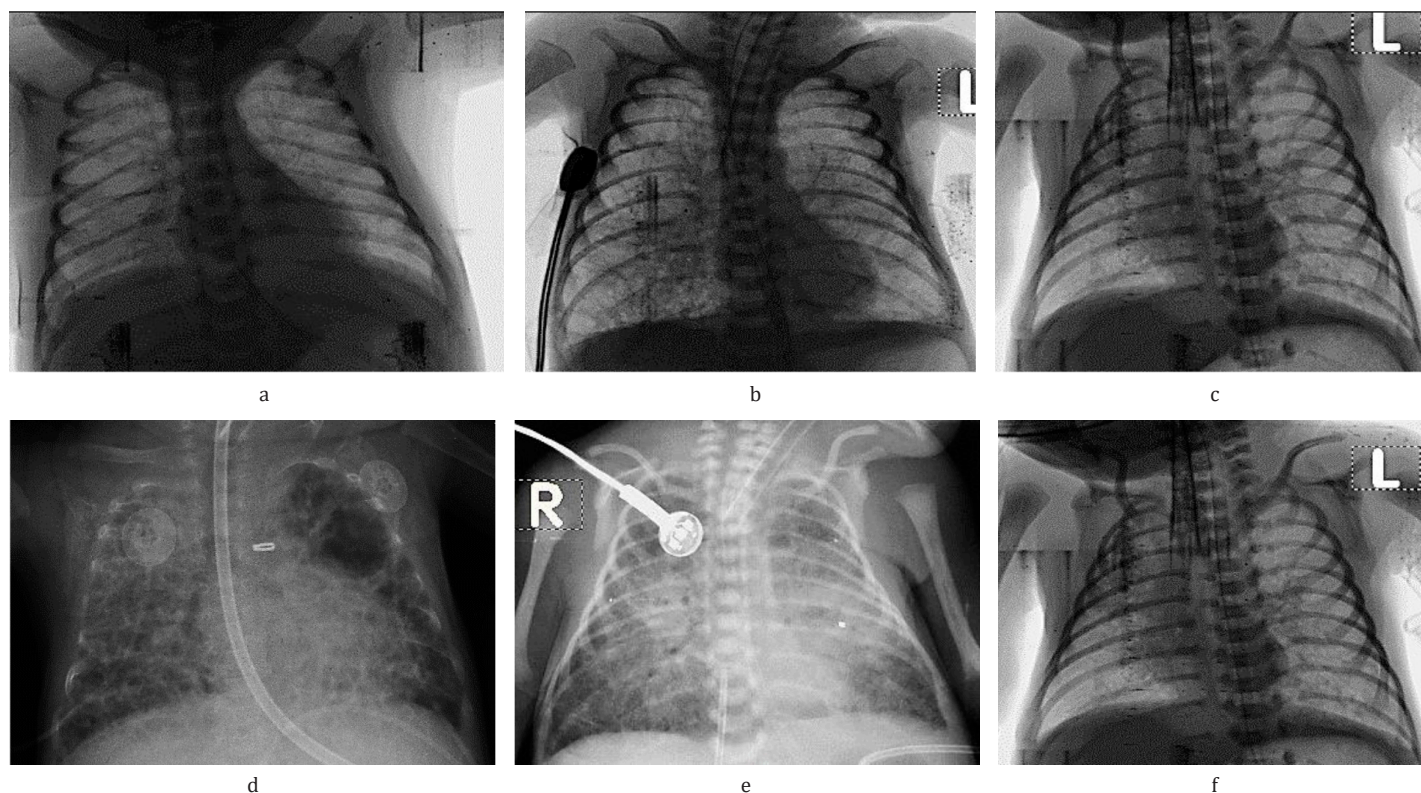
Various radiographic images with different changes in premature infants with bronchopulmonary dysplasia
